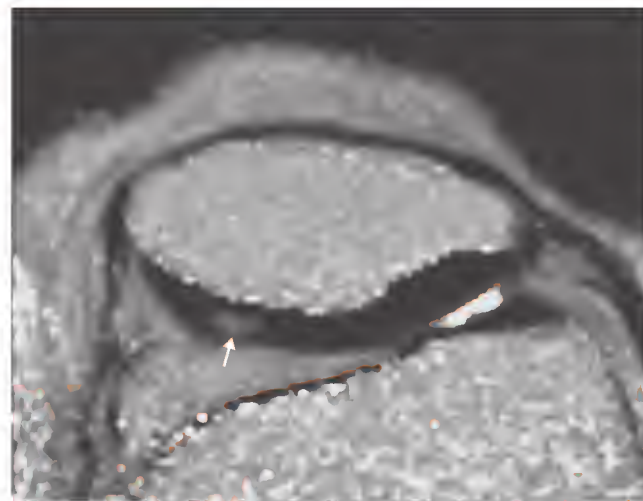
T2-mapped magnetic resonance image of the knee demonstrating early intrasubstance degeneration of the patellar cartilage seen as prolonged T2 signal (arrow).
